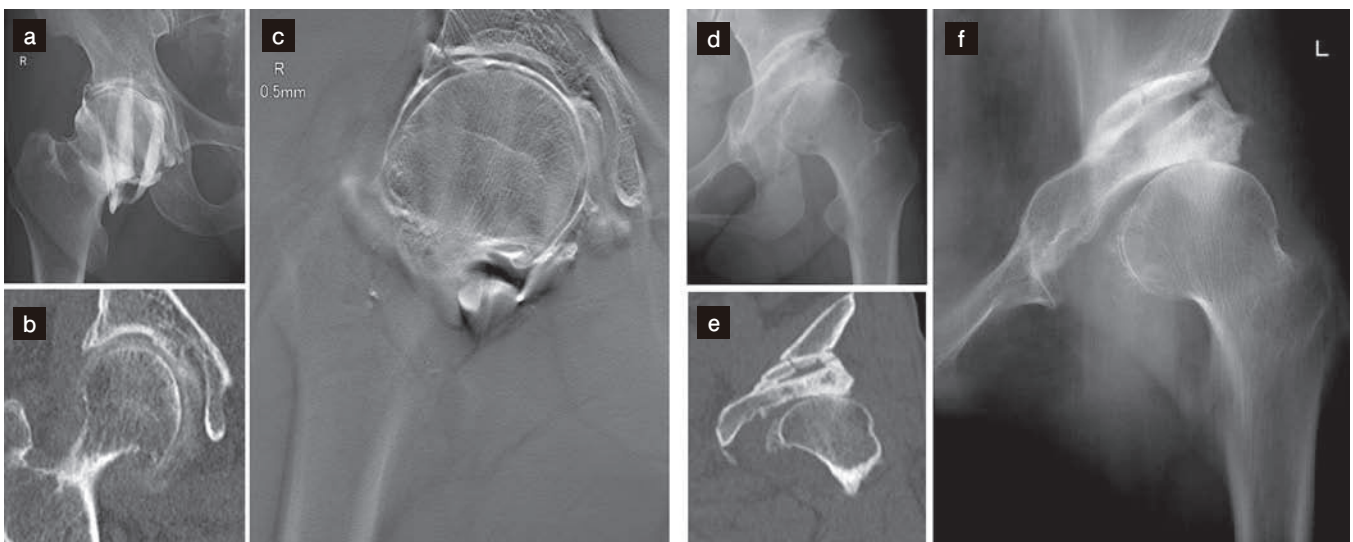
Comparison of hip joint tomosynthesis and CT
